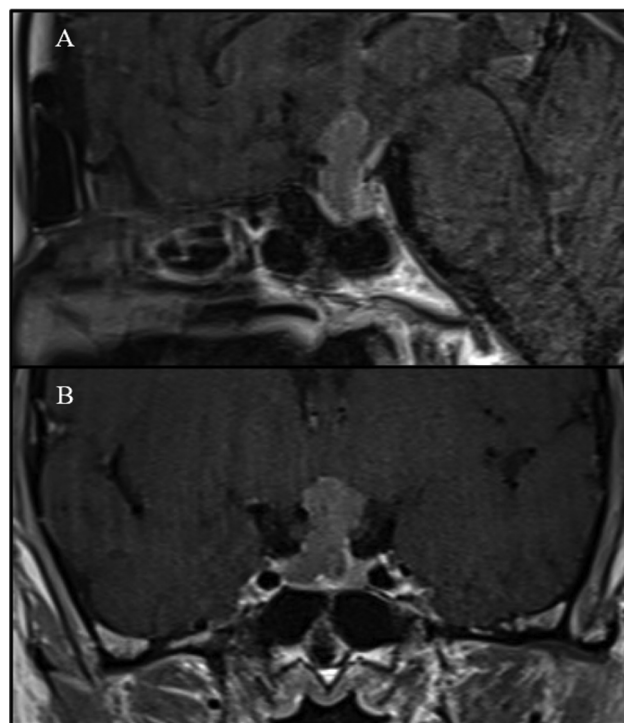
Magnetic resonance imaging with sagittal (A) and coronal (B) sections. It revealed a sizable sellar and suprasellar mass measuring 22 × 12 × 9 mm, consistent with a pituitary macroadenoma. It minimally extends into the cavernous sinuses (Knosp grade 1) without encasing the internal carotid artery, displaces the optic chiasm superiorly, and slightly deviates the pituitary stalk to the left.
